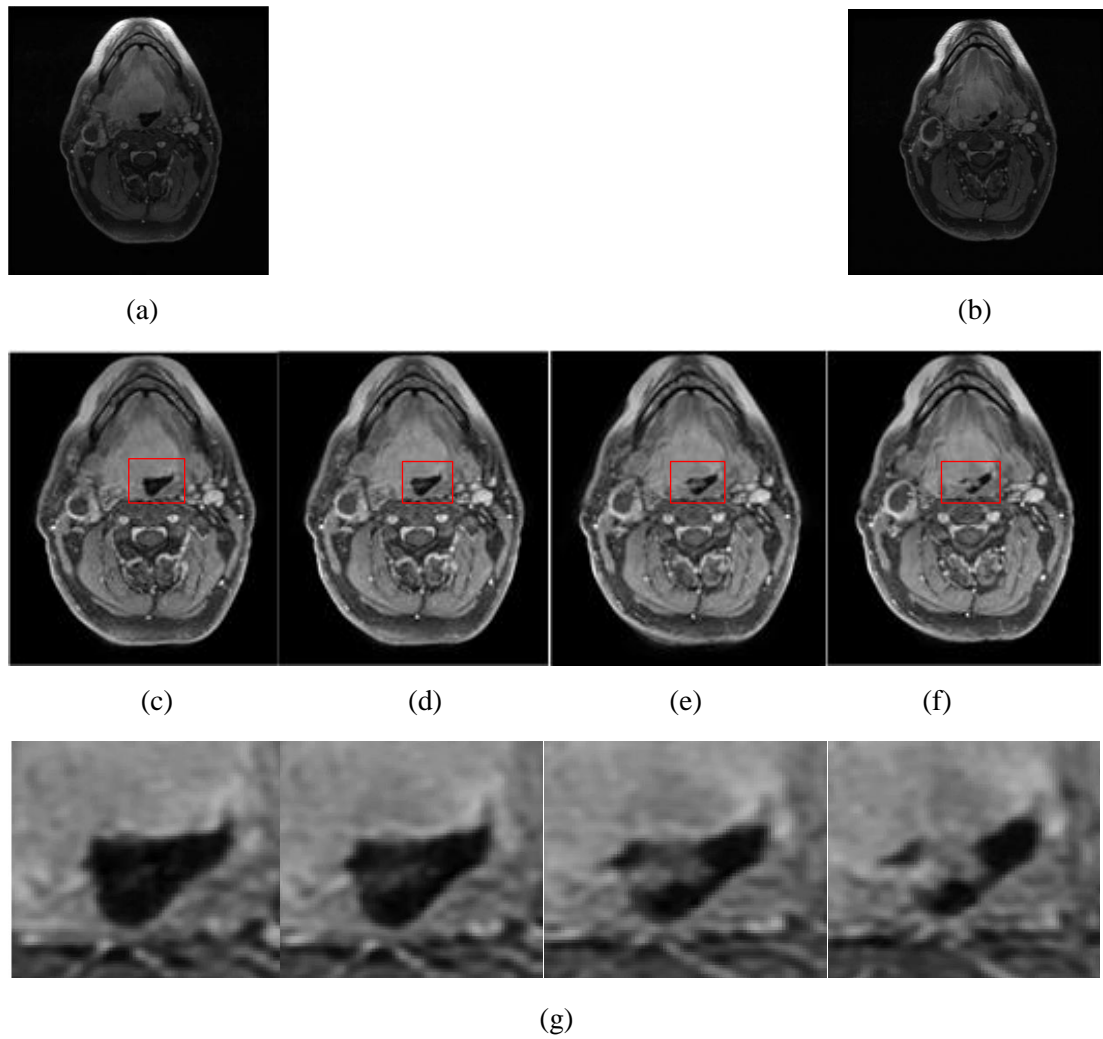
(a) and (b) MRI slices before pre-processing, (c) and (f) MRI slices after pre-processing, (d) and (e) interpolated MRI slices using Fourier interpolation, (g) zoom-in version of MRI slices near the throat region (red region) to demonstrate expected change of topology (splitting) across the throat region. [77] © 2015 IEEE
